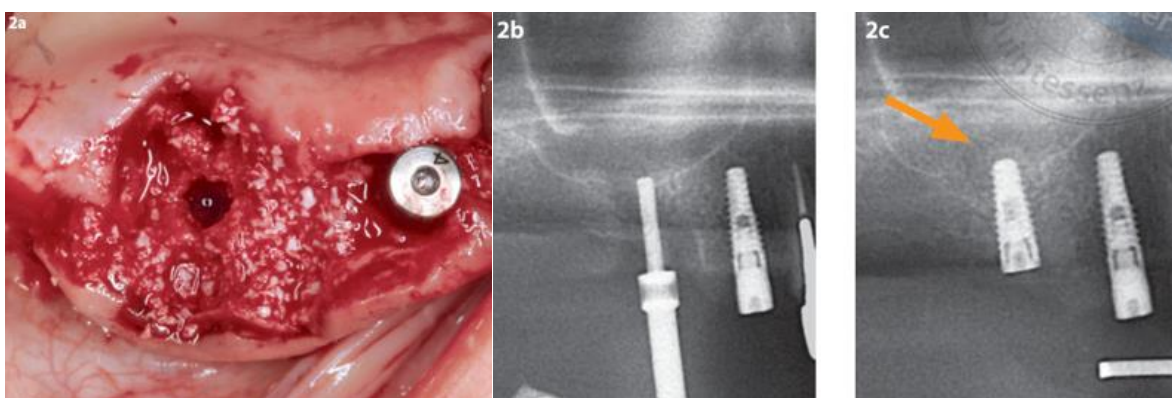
Transcrestal approach for sinus augmentation (a) Osteotomy preparation, simultaneously to the molar extraction (b) Penetration to the sinus with an osteotome (c) Postoperative radiograph of the placed implant with the bone graft above the implant apex (20).
